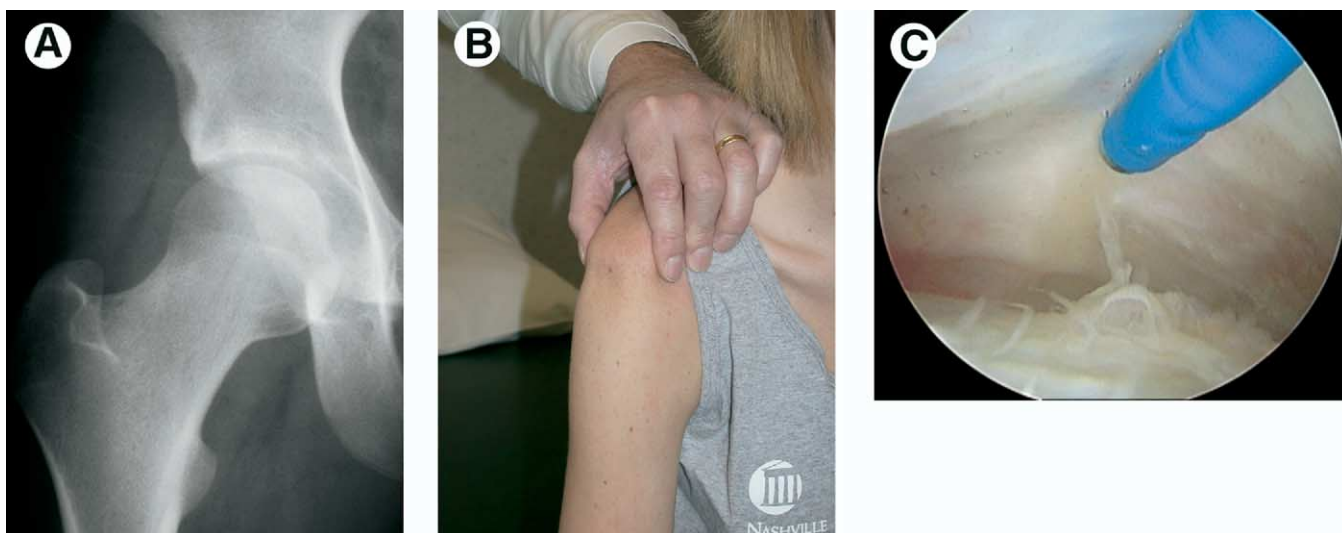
A 19-year-old woman had undergone two previous arthroscopic procedures on her right hip for reported lesions of the ligamentum teres. After each procedure, she developed recurrent symptoms of “giving way.” (A) Radiographs revealed normal joint geometry. (B) She was noted to have severe diffuse physiologic laxity best characterized by a markedly positive sulcus sign. (C) With objective evidence of laxity and subjective symptoms of instability, an arthroscopic thermal capsulorrhaphy was performed, accessing the redundant anterior capsule from the peripheral compartment. Modulation of the capsular response was controlled by a hip spica brace for 8 weeks postoperatively with a successful outcome. (Figure © J.W. Thomas Byrd.) (Color version of figure is available online.)
